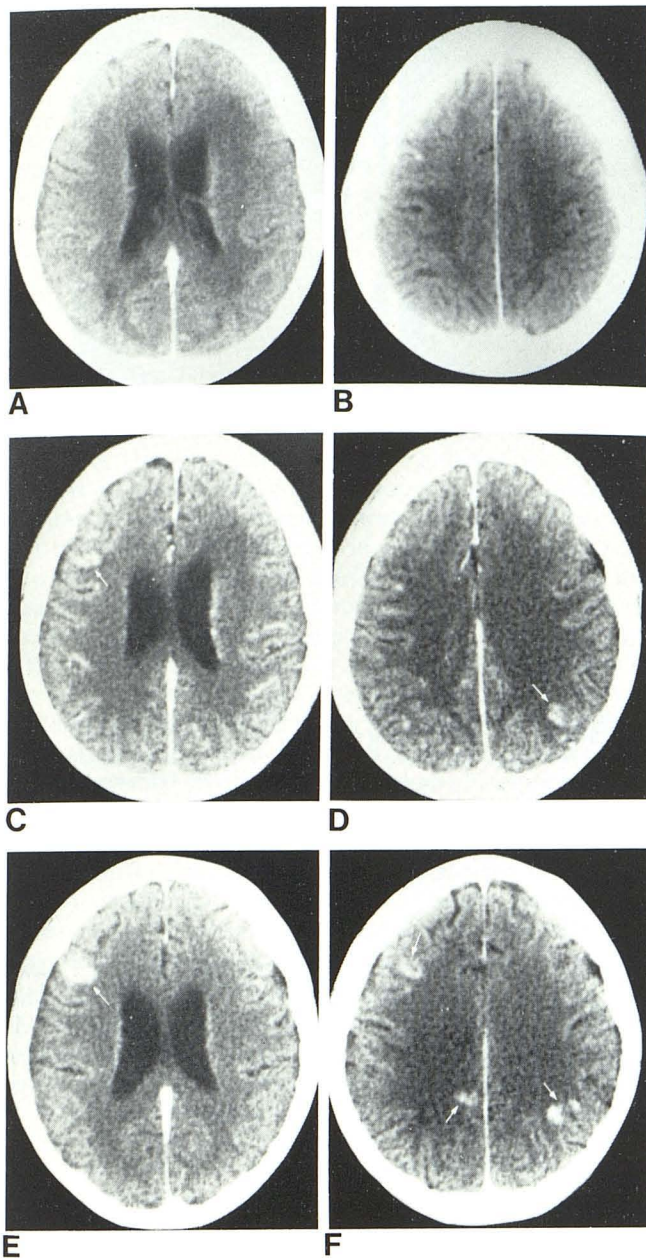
Immediate single-dose (A and B), immediate double-dose (C and D), and delayed double-dose (E and F) contrast scans show importance of CT technique in same patient as in fig. 4. On these selected CT images more lesions are visualized and other lesions become more apparent (arrows) as amount of contrast and time between injection and scanning are increased.
